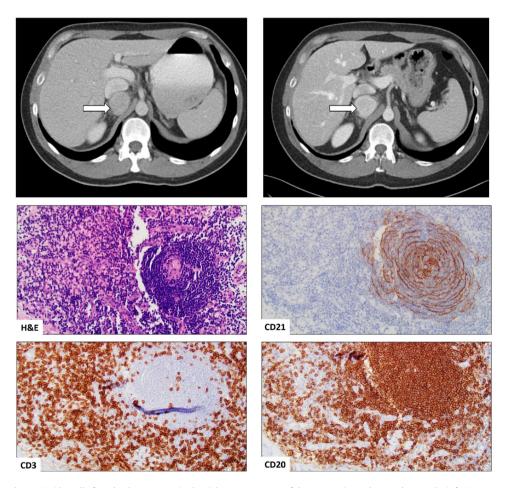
A 38-year-old female was incidentally found to have a mass in the right upper aspects of the retroperitoneal space deep to the inferior vena cava on CT scan obtained for right lower quadrant pain secondary to appendicitis. The mass was biopsied and demonstrated the HV variant of UCD. The mass was not resected, and the patient has remained asymptomatic. CT scans at presentation and 6-year follow up show no change in the tumor dimensions.
